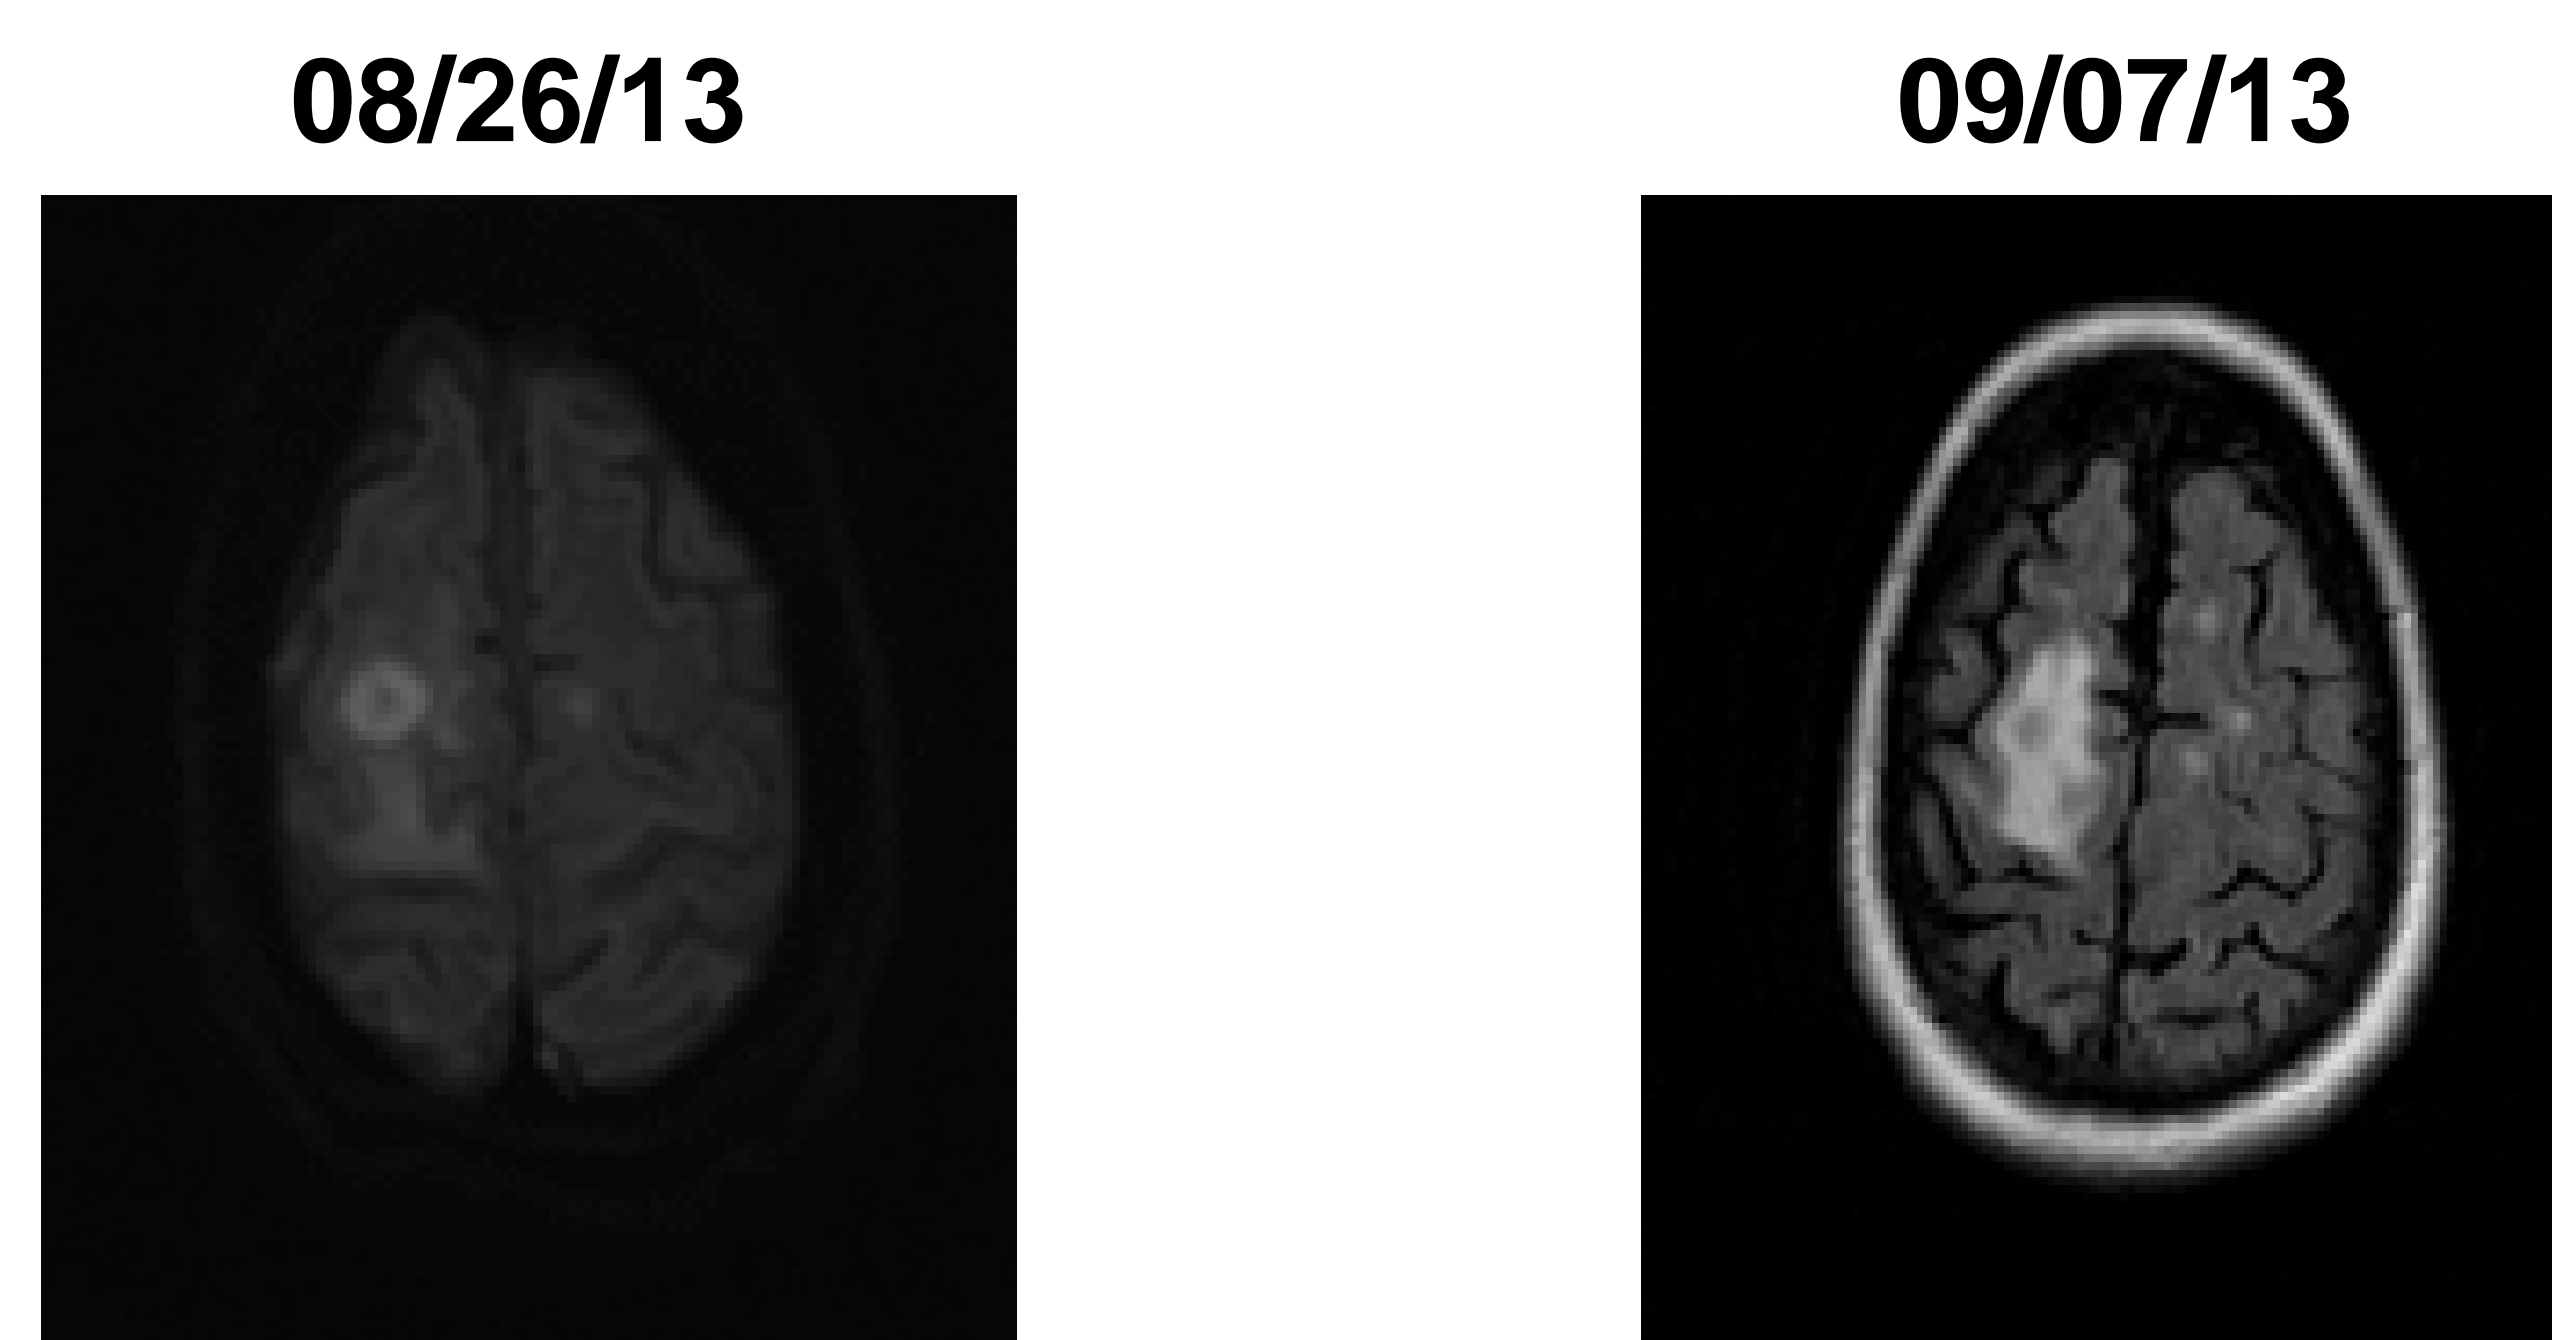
MRI diffusion-weighted images
